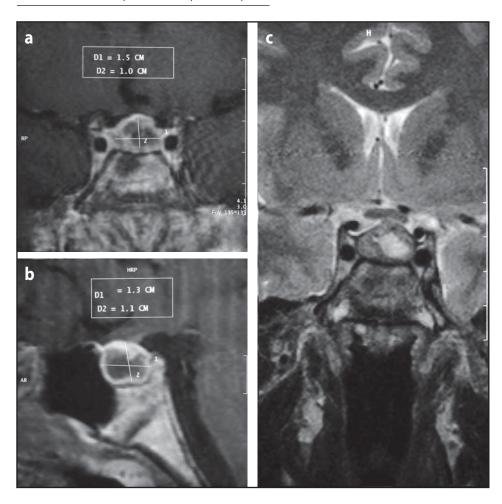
MRI of pituitary gland:
